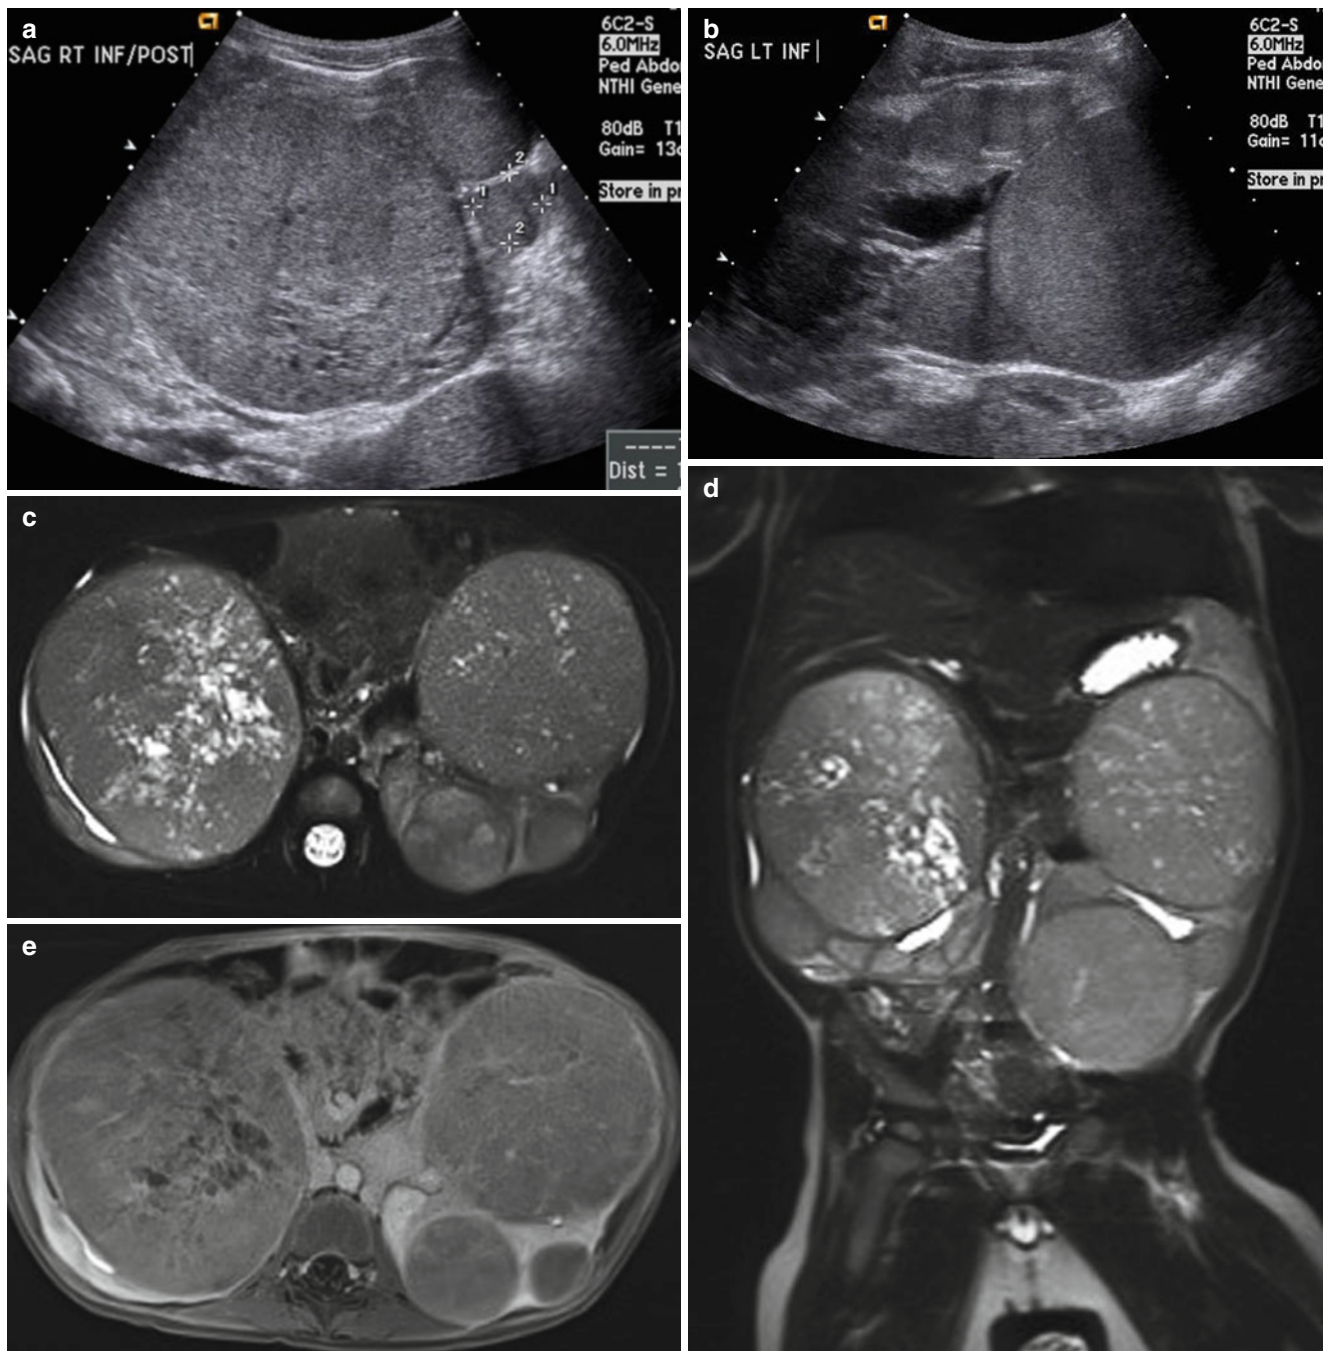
Nephroblastomatosis and Wilms tumor in a 2-year-old boy. (a and b) Longitudinal US of the right and left kidneys shows exophytic, homogeneous echogenic masses in the lower poles of both kidneys. T2-weighted axial (c) and sagittal (d) MR images demonstrate
